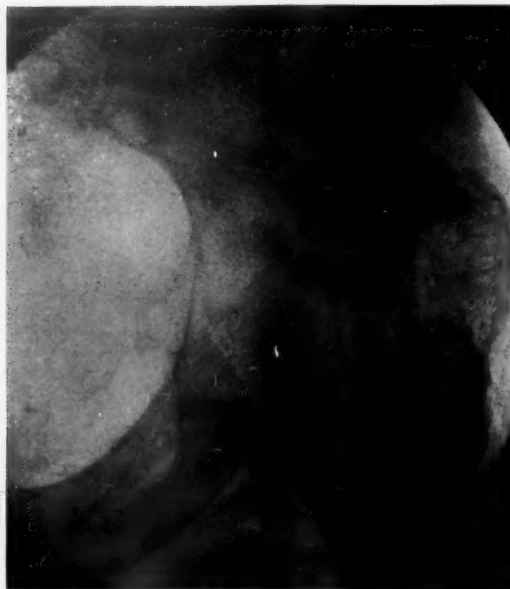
Case III. Metaplastic osteomalacia, adult type. X-ray showing displacement, distortion of contour, and disease of upper end of right femur.
